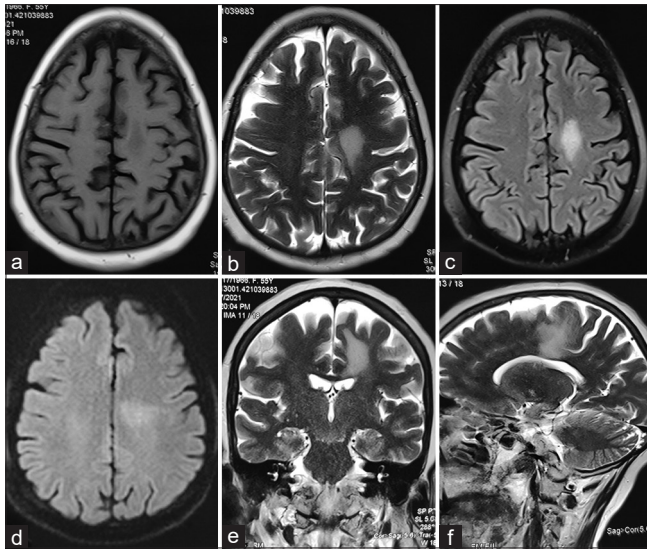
MRI of the brain (axial sections) depicts a periventricular hypo- to iso-intense lesion on T1W sequence (a); the white matter lesion is hyperintense on T2W (b) and FLAIR (c) sequences and shows minimal diffusion-restriction on diffusion-weighted imaging (DWI) (d) sequence. On T2W coronal section (e), the subcortical hyperintense lesion can be seen to involve the corpus callosum; no contrast enhancement is evident in T1W-gadolinium enhanced image (f)
